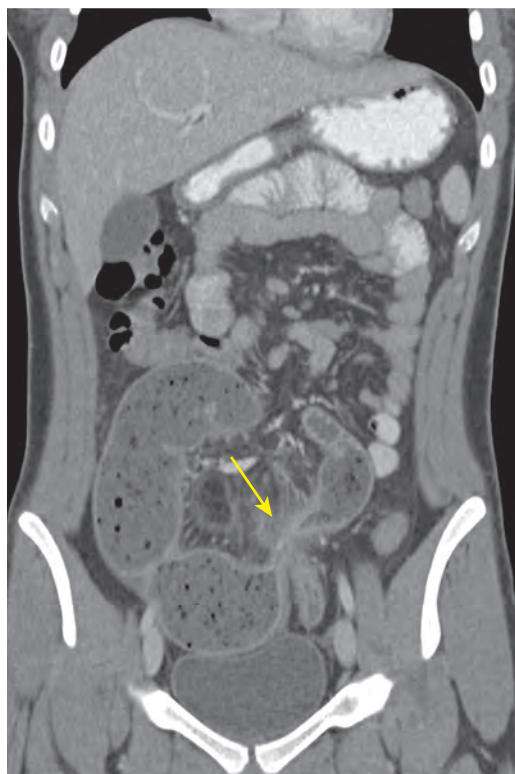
Crohn's disease causing partial small bowel obstruction. A. Coronal reformatted CT image shows a stricture (arrow) of the midileum, with proximal dilation and the small bowel feces sign.
